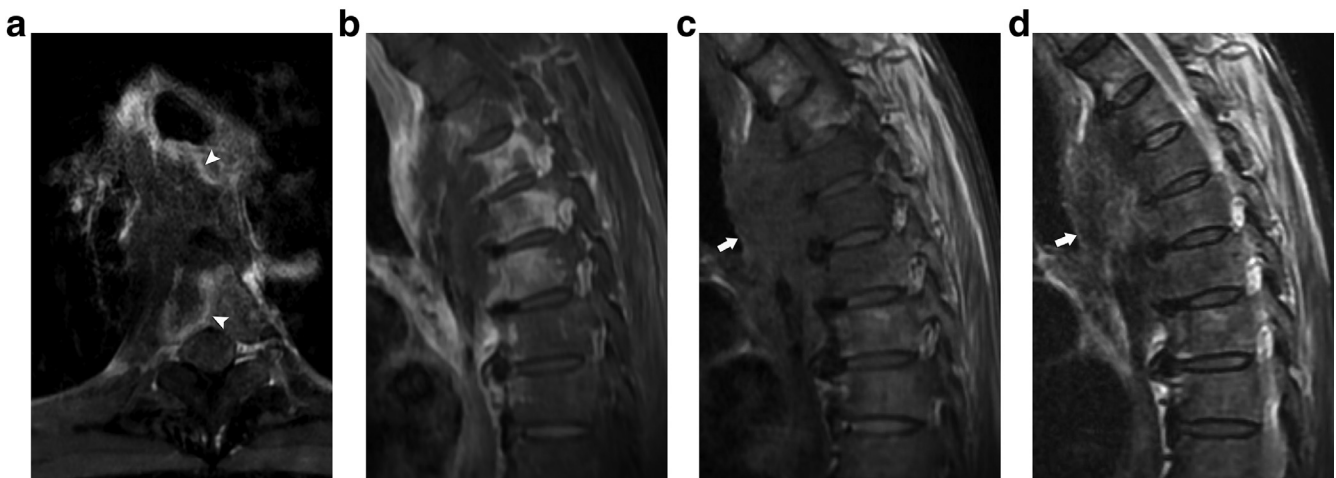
(A) Postcontrast axial T1-weighted MRI with fat suppression reveals an ill-defined low-signal intensity mass with peripheral rim enhancement (arrowheads) including the thoracic spine. (B) Postcontrast sagittal T1-weighted MRI with fat suppression shows increased signal intensity of the adjacent third to sixth thoracic vertebral bodies suggestive for bone marrow involvement. The mass (arrow) has diffuse low-signal intensity in T1-weighted MRI (C) and mixed high- and low-signal intensity in T2-weighted MRI (D).
